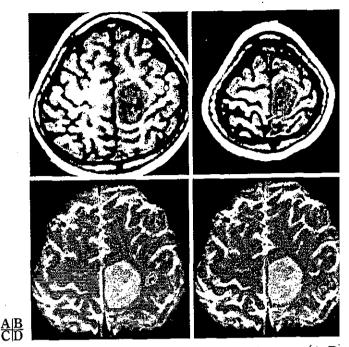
Preoperative magnetoencephalograms (A, B) and functional MR images (C, D)
